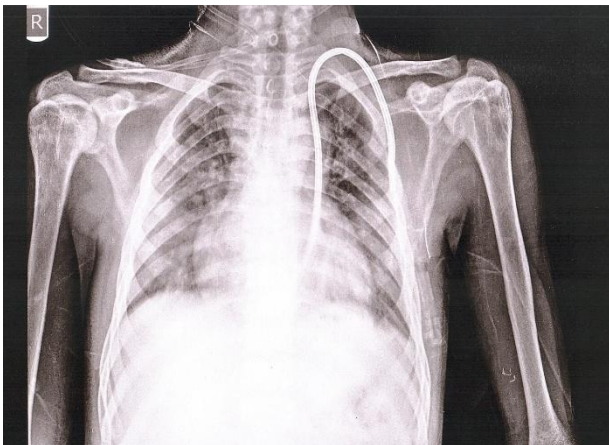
Post-procedural chest radiograph demonstrating the tunneled hemodialysis catheter coursing vertically along the left mediastinal border through a PLSVC. The catheter tip projects over the coronary sinus–right atrial junction, confirming successful placement via the anomalous venous pathway.
